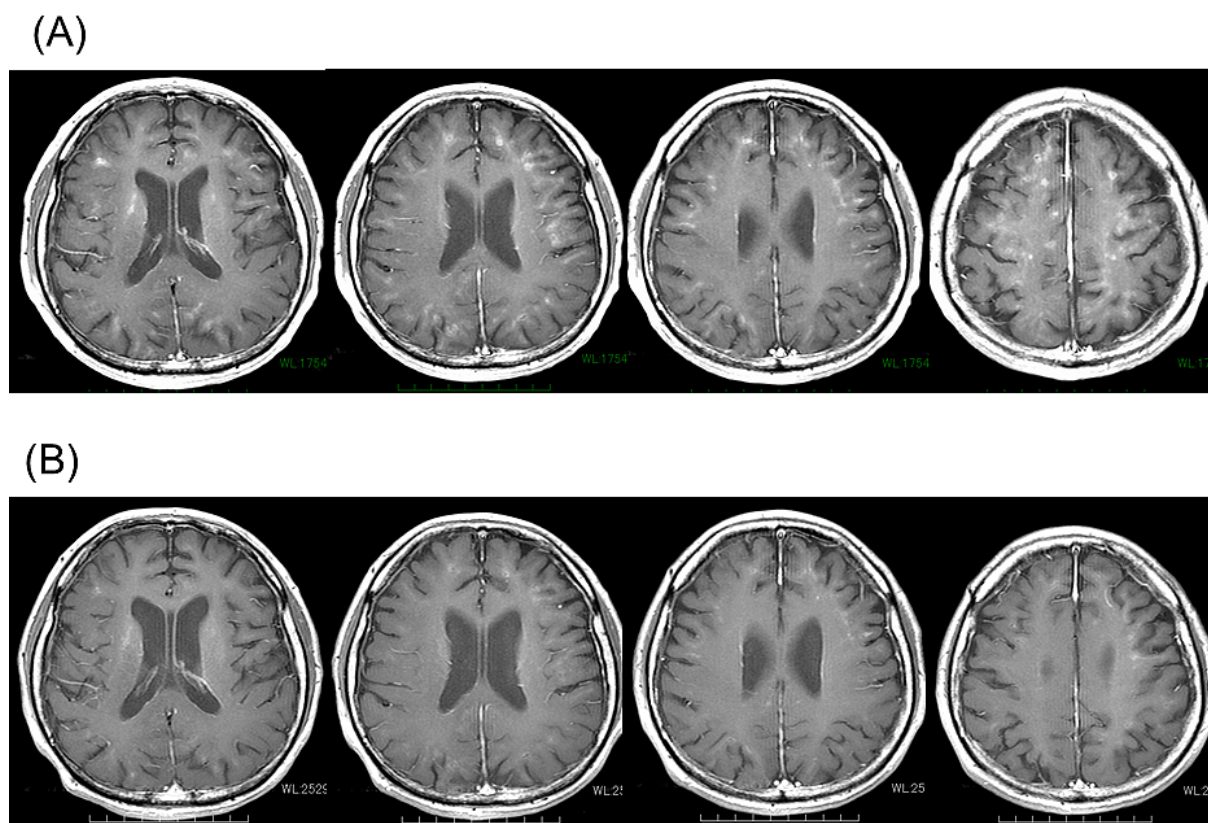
Enhanced MRI findings before (A) and 1 month after (B) treatment with betamethasone and cyclophosphamide. Multiple enhancement areas in the subcortical region and basal ganglia (high-intensity areas in T1) (A) disappeared after the treatment (B).
